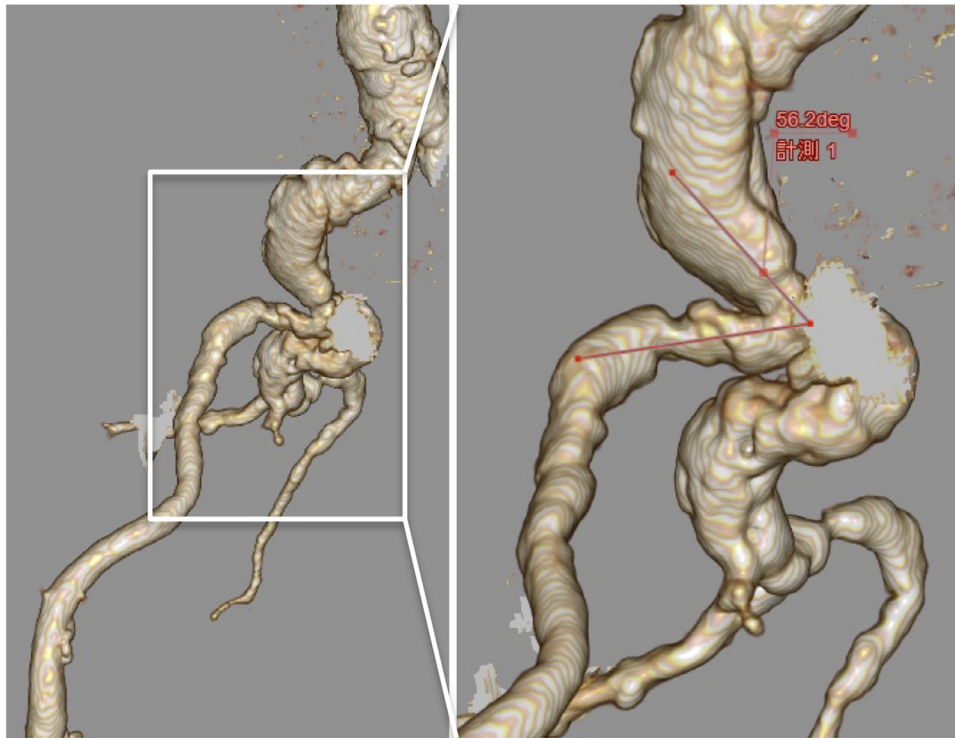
The 3-dimensional CT angiography showed a severe bend of 124 degrees at the rupture site.
